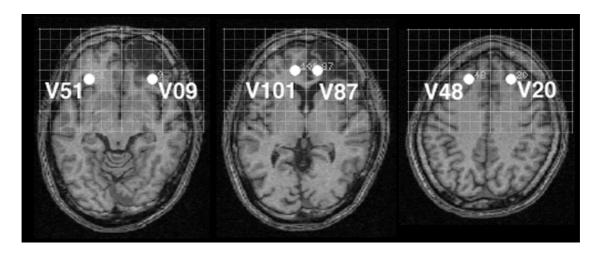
MR image of Case No.9 showing contusional change in the right frontal lobe. Lattices of 0.3 cm width were virtually set on the 3 dimensional MR image space. The currentodensitogram from virtual channel on each lattice point was monitored. The location of virtual channels being demonstrated in Figure 2b were specified.
